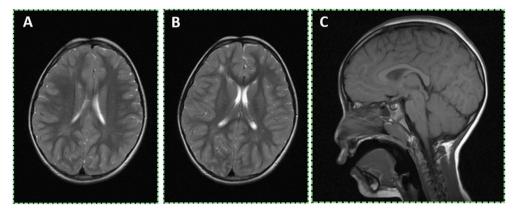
Brain magnetic resonance imaging (MRI) findings in the patient at age 4 years: T2 axial (left, middle) and T1 sagittal (right) reveals white matter hyperintensities of the peritrigonal and periventricular region adjacent to the right lateral ventricle.
